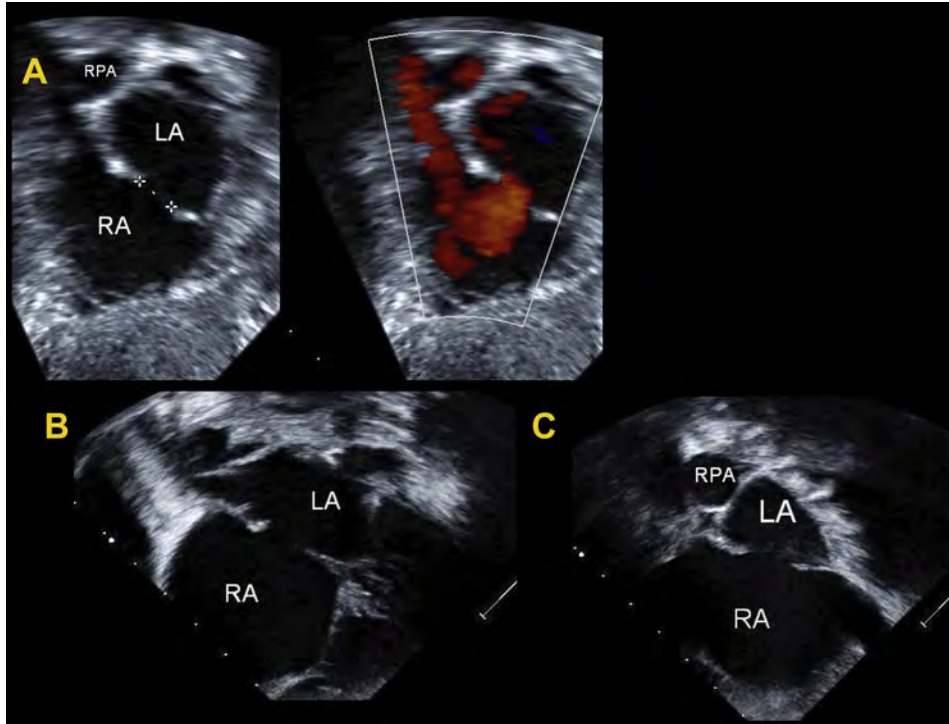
(A and B) Examples of ostium secundum by 2D TTE (*left*) and with color Doppler (*right*) in the subcostal left anterior oblique view. (A) Measurement of the ASD diameter (*left*) and left to right color Doppler flow (*right*). (C) Sagittal subcostal view in a patient with secundum ASD. RPA, right pulmonary artery.
